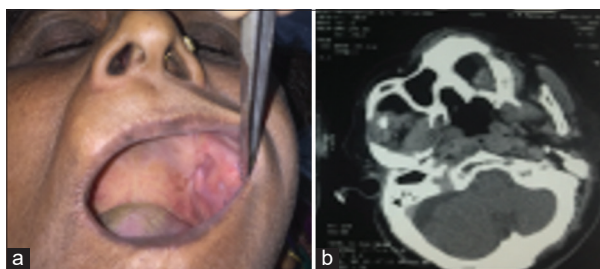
(a) Intraoral picture showing small opening in the left poster-back teeth region, (b) Computed tomography scan with residual cyst in the maxillary sinus (Case 7)
